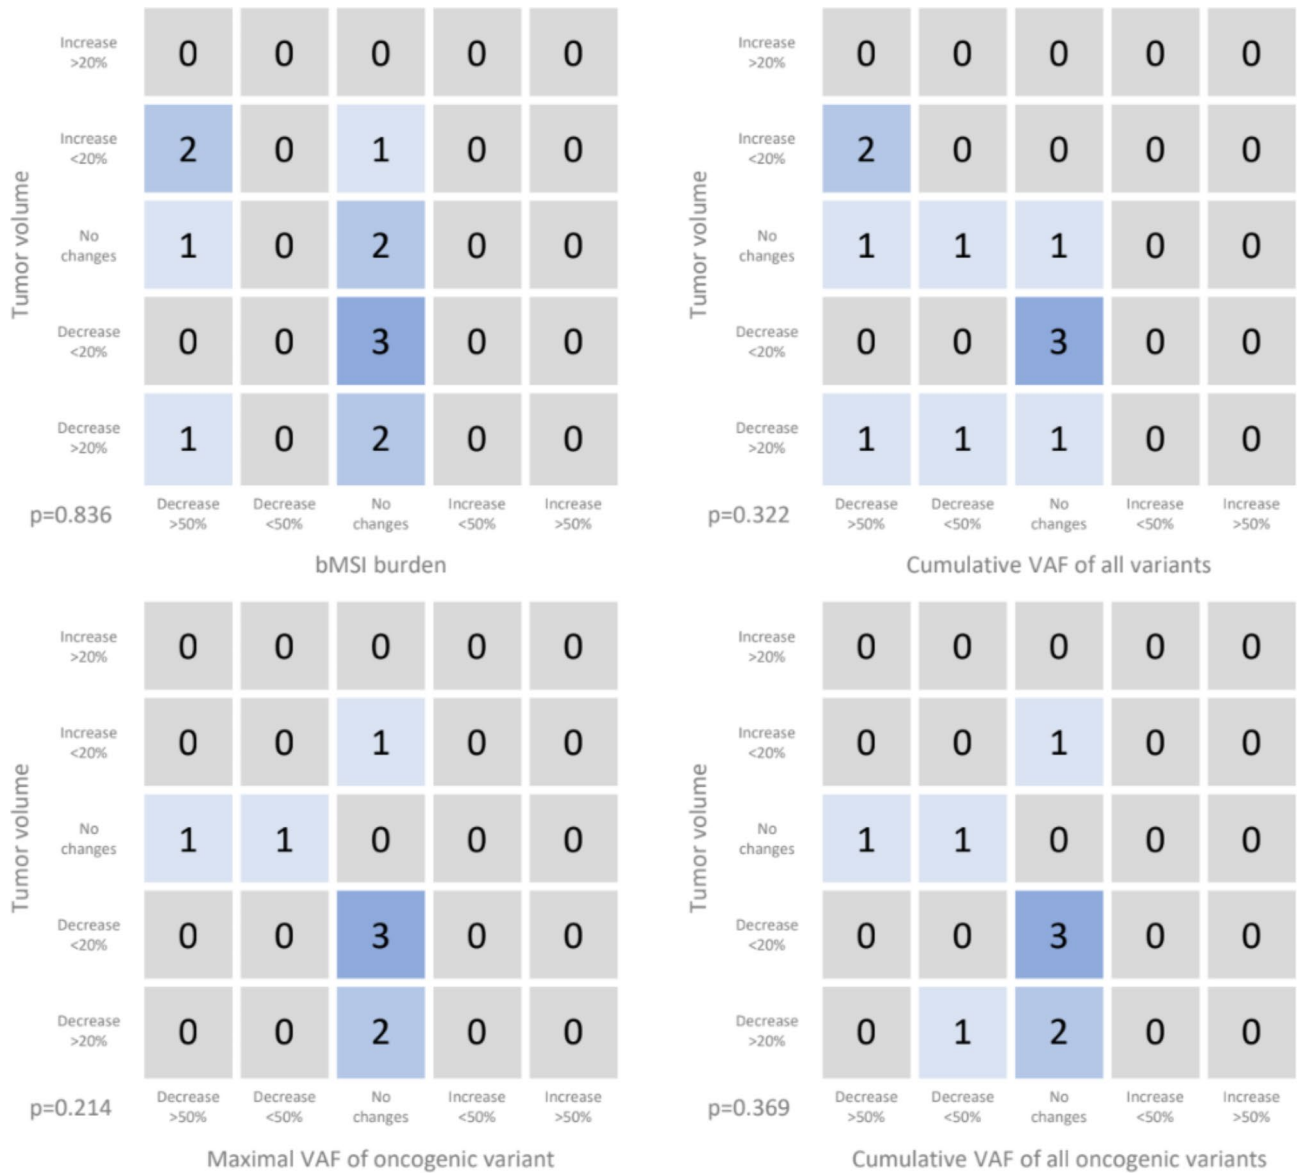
Connection of tumor volume radiological changes with changes in MSI-score and VAFs in the blood plasma. One point was added to the corresponding cell of the table if the dynamics of CT and ctDNA parameters coincided. The following ctDNA parameters were used: bMSI, cumulative VAF of all variants, maximal VAF of oncogenic variant, cumulative VAF of all oncogenic variants.
